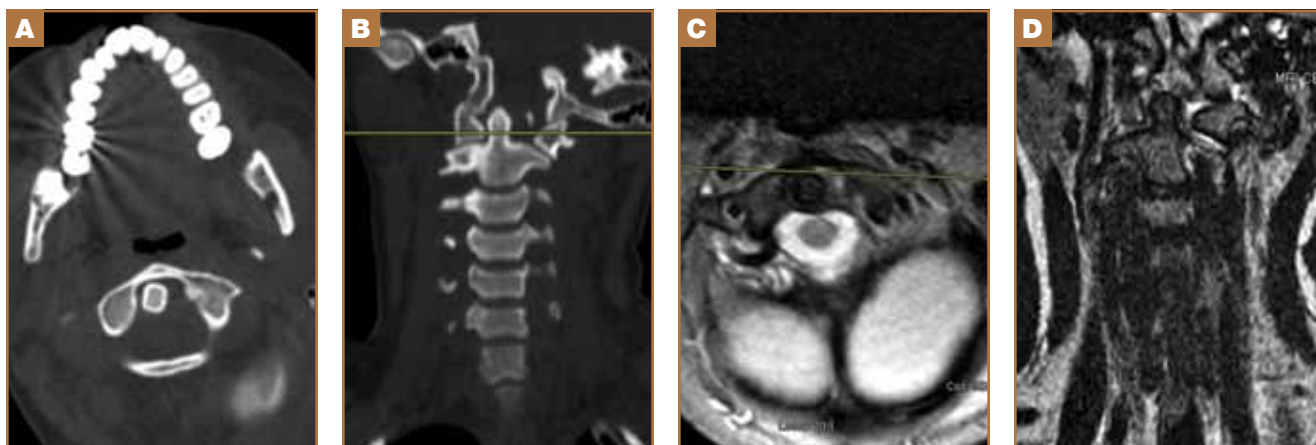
Imaging findings at initial visit. (A) Axial CT scan showing C1/C2 rotatory subluxation. (B) Coronal CT reconstruction showing C1/C2 subluxation and a bone fragment lateral to the left side of the odontoid process with asymmetric widening of the left lateral atlanto-dens interval. (C) Axial MRI without contrast showing intact transverse ligament of the atlas. (D) Coronal MRI showed no identifiable ligamentous injury.
